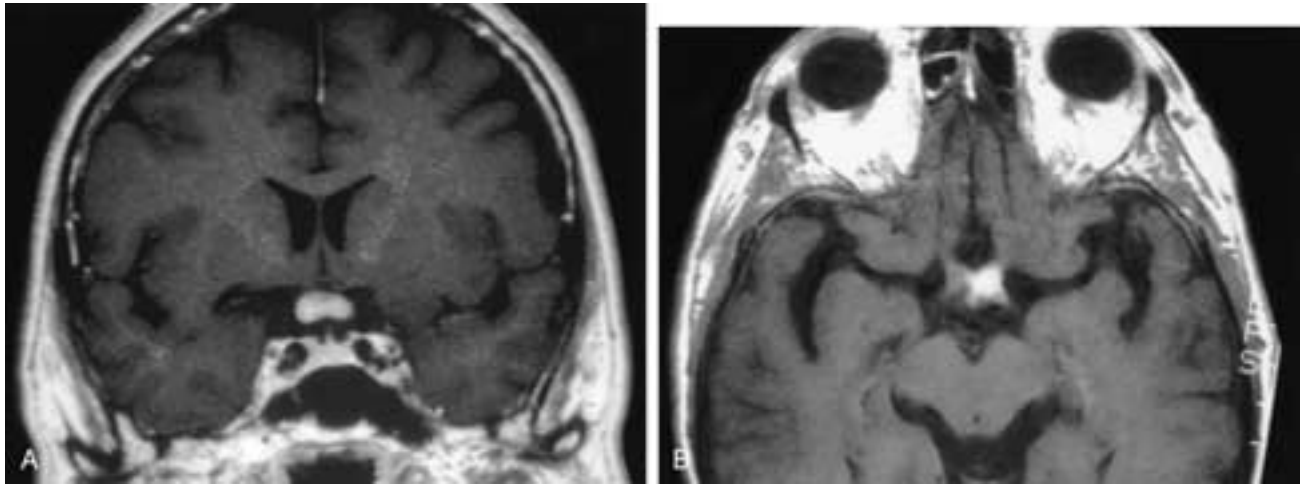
Lyme disease involving the optic chiasm in a 66-year-old female. Coronal (A) and axial (B) T1-weighted images after contrast injection show enhancement and enlargement of the optic chiasm. A is before treatment and B is 1 week after the beginning of treatment, showing some response to antibiotic therapy.
